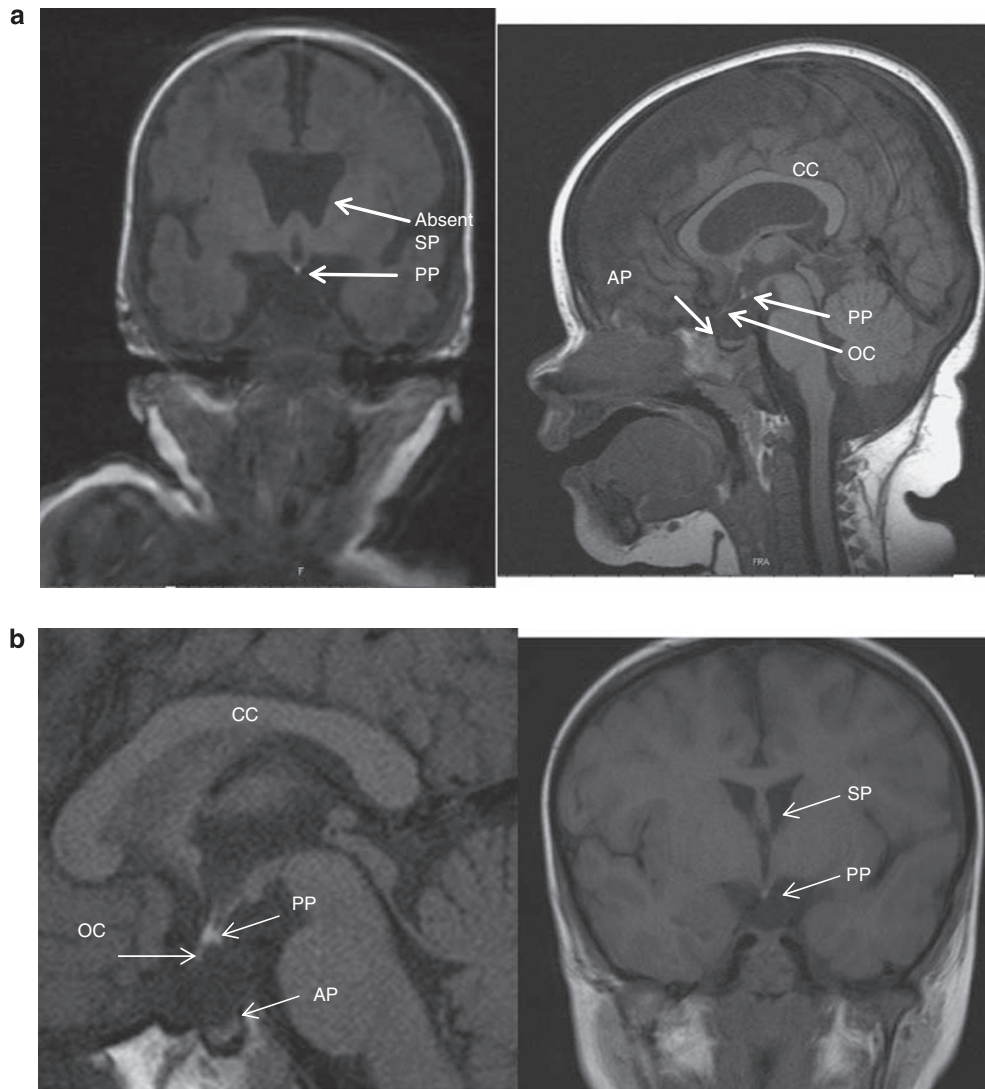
MRI appearances of septo-optic dysplasia. (a) Anterior pituitary hypoplasia and absent infundibulum associated with bilateral optic nerve hypoplasia. The posterior pituitary is ectopic. There is an absence of the septum pellucidum. (b) Ectopic posterior pituitary, anterior pituitary hypoplasia, absence of the infundibulum and partial absence of the septum pellucidum associated with optic nerve hypoplasia. CC, corpus callosum; AP, anterior pituitary; PP, posterior pituitary; SP, septum pellucidum; OC, optic chiasm.
